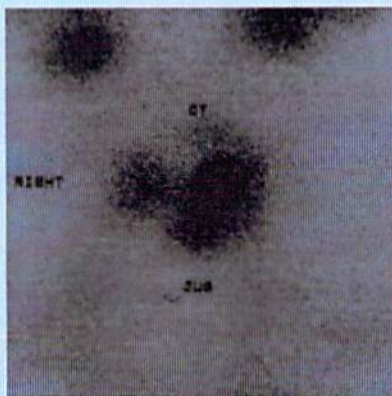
Thyroid scintigraphy showed a thyroid remnant
